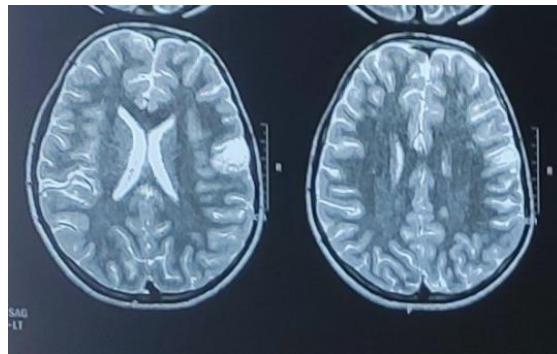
T2 weighted MRI showing hyperintense lesion
